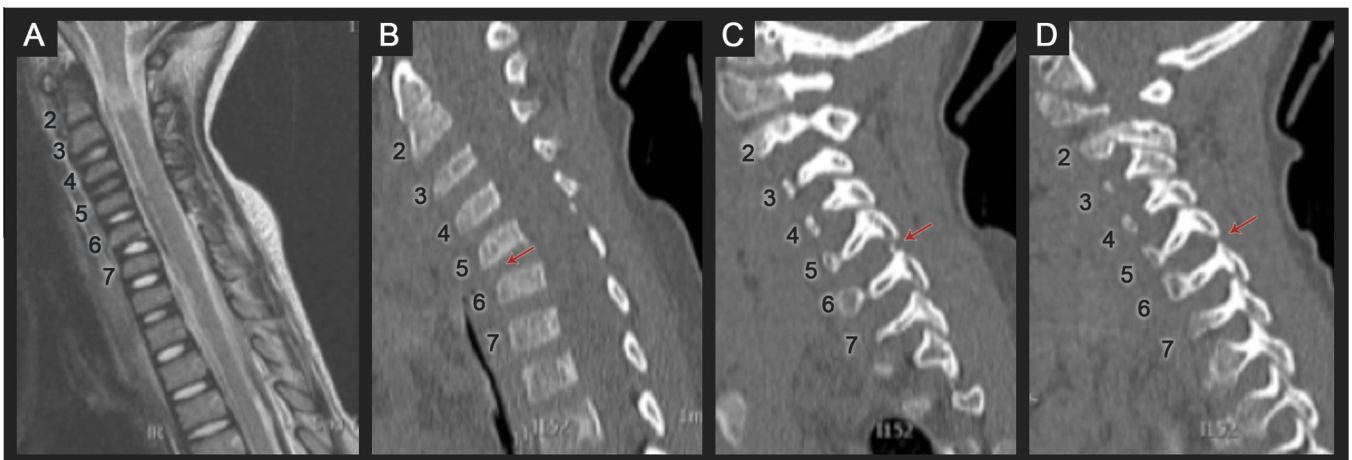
Follow-up imaging 3 months after initial injury. (A) Sagittal MRI demonstrating myelomalacia at the C1–C2 level. (B–D) Sagittal CT scan demonstrating focal kyphosis at C5–C6 (B) with bilateral facet disruption (C,D), left C5 facet fracture (C) and 2 mm anterolisthesis of C5 on C6.
